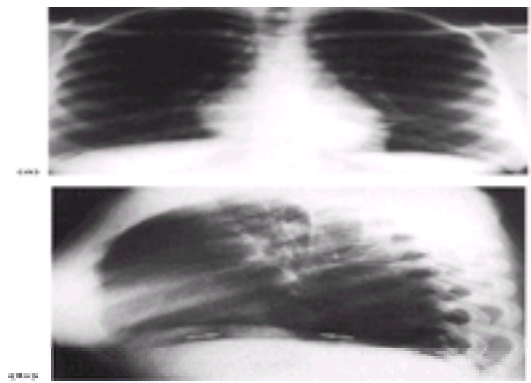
(a) Chest radiograph obtained because of a cough in a 14-year-old girl revealed an unrelated retrocardiac shadow (arrows); (b) the lateral radiograph confirmed its presence anterior to the spine (arrows).
